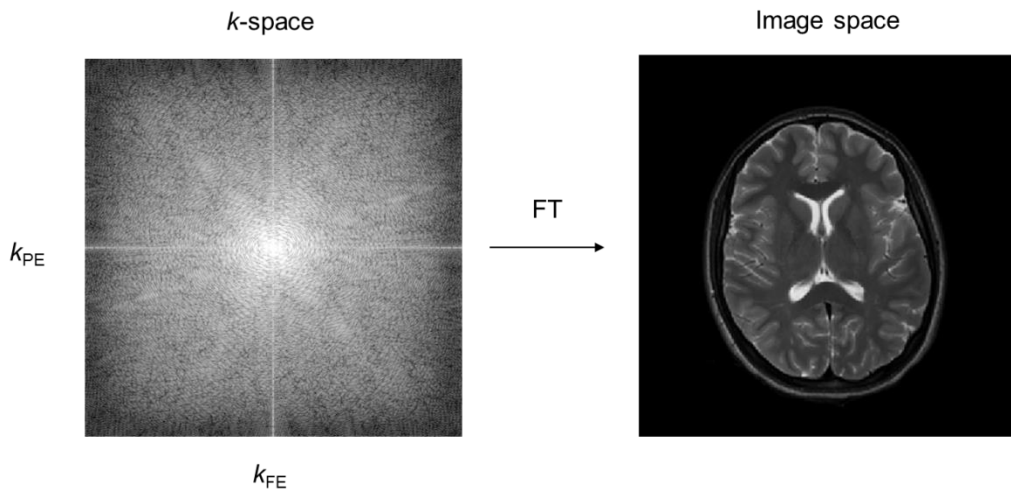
Generating the MR image. Conversion of raw k -space data to image space data by a 2D Fourier transform. The presented example is from a T₂-weighted imaging sequence with a Cartesian k -space trajectory.
